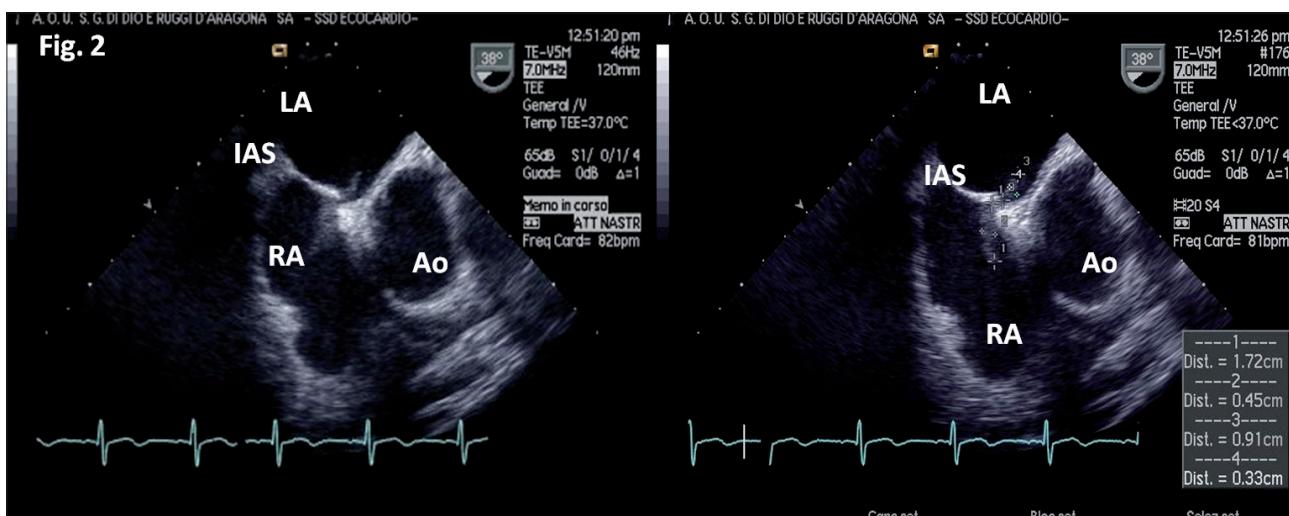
A second transesophageal echocardiography revealed the decrease of dimensions of the thrombus particularly in left atrium (9.1 x 3.3 mm) but also in right atrium (17.2 x 4.5 mm). LA, left atrium; RA, right atrium; IAS, interatrial septum; Ao, aorta.
